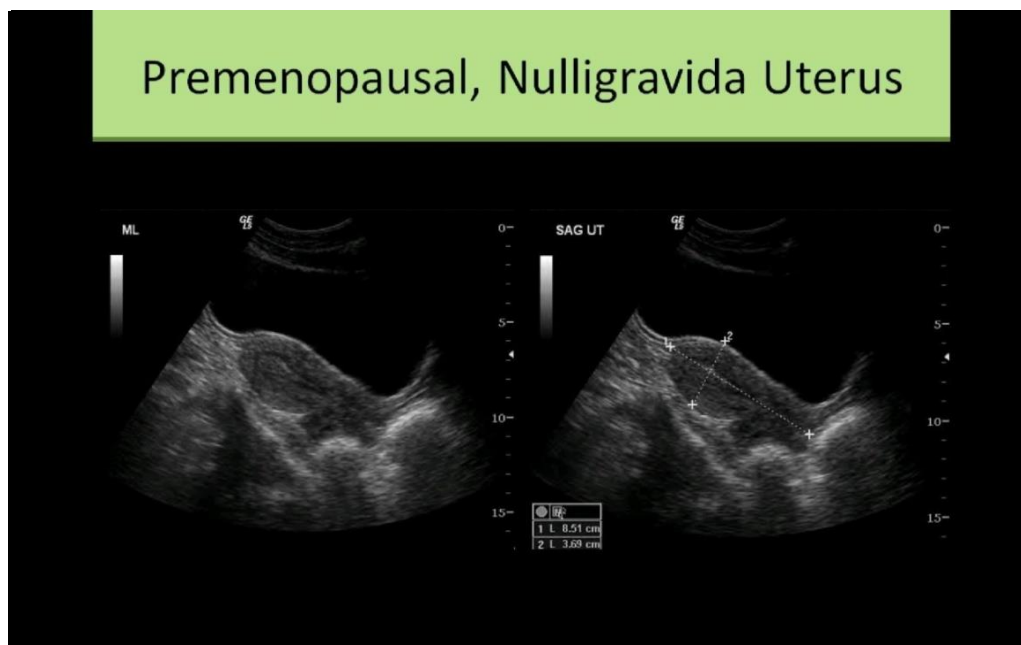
shows ultrasound image of premenopausal nulligravida uterus . Alfred Abohamed 2007.
